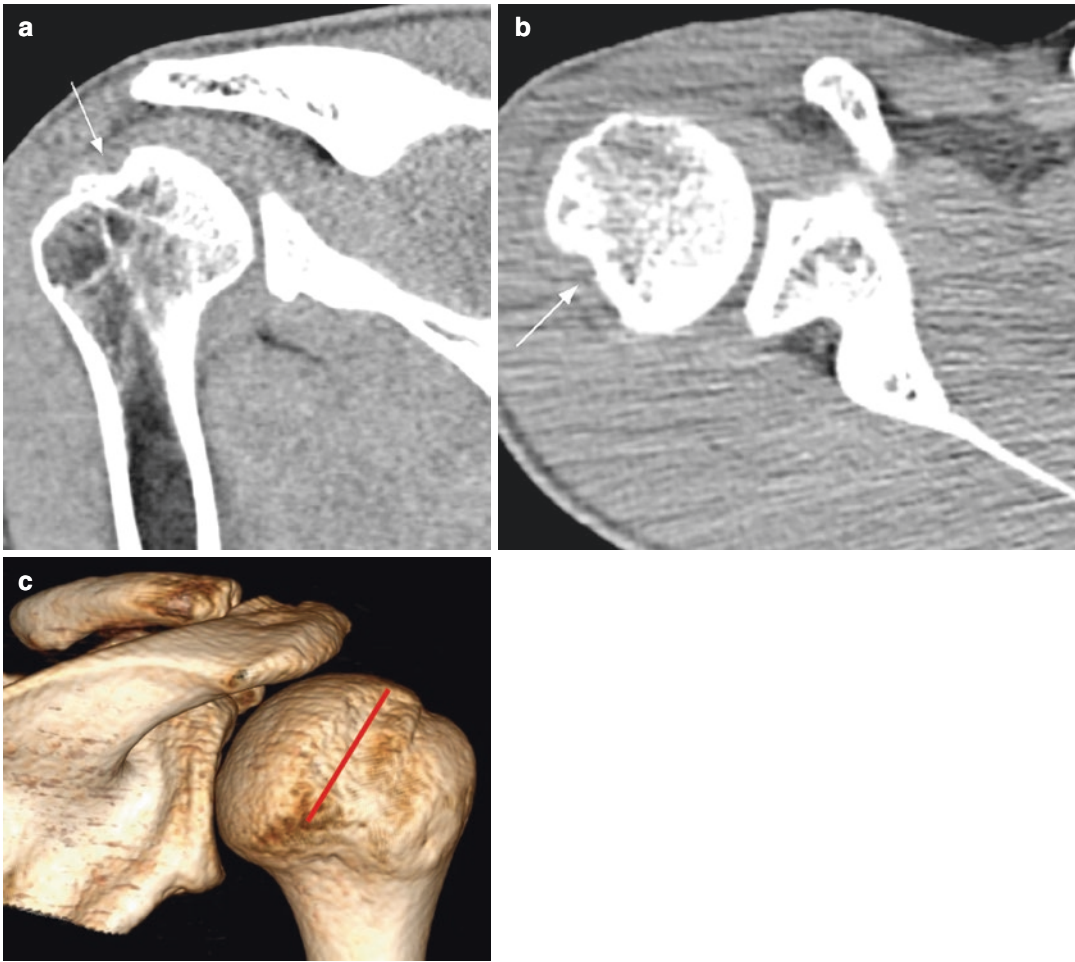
CT scans of a right shoulder with a Hill–Sachs lesion (arrow). Linear measurements (length, width, and depth) are measured on standard 2D CT scans (a, b).
